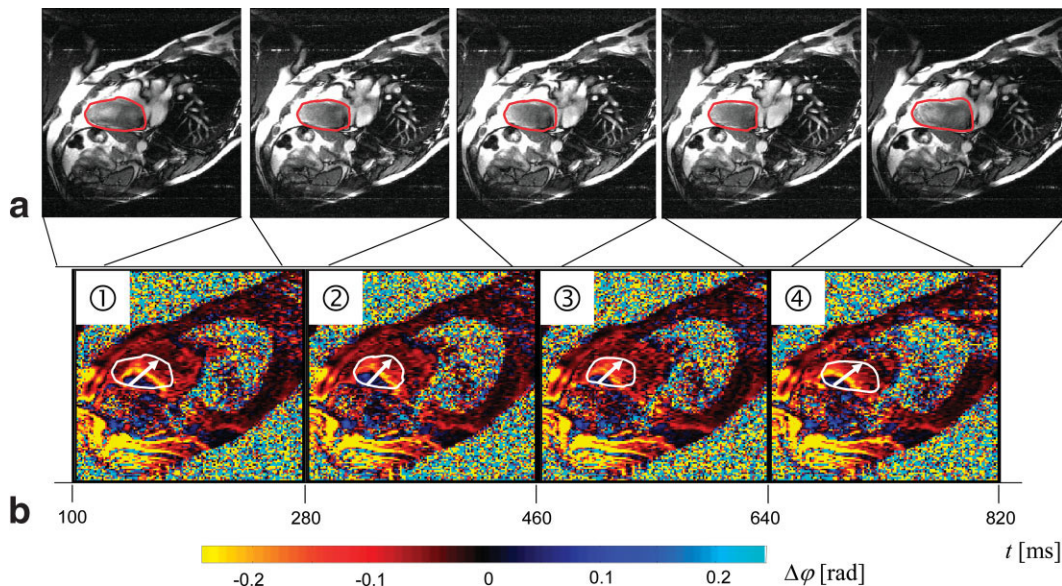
Transmural wave in the IVS of a volunteer externally induced by 50-Hz vibrations of the chest. a: cine bSSFP-MR images for anatomical reference. The position of the IVS is demarcated by the red line. In this region the myocardium remains within the image plane of 5-mm thickness. b: Real part of the complex phase-difference contrast images with approximately 180-ms temporal resolution showing the externally induced vibration in the IVS ($u \approx 40$ μ m). White arrows indicate the direction of wave propagation that is visible in animations that correspond to each phase image and are provided.
